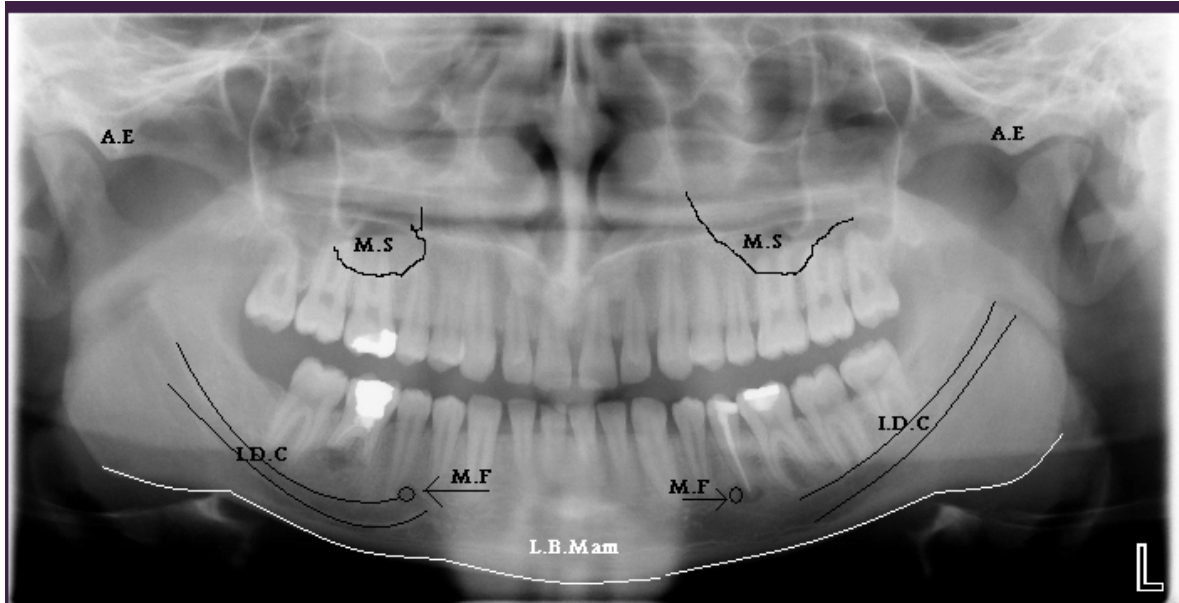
Digital panoramic radiograph shows the five anatomical landmarks: A.E: Articular eminence. M.S: lower and anterior border of the maxillary sinus. I.D.C: superior and inferior cortex of the mandibular canal. M.F: superior and inferior margin of the mental foramen. L.B. Man: lower border of the mandible
